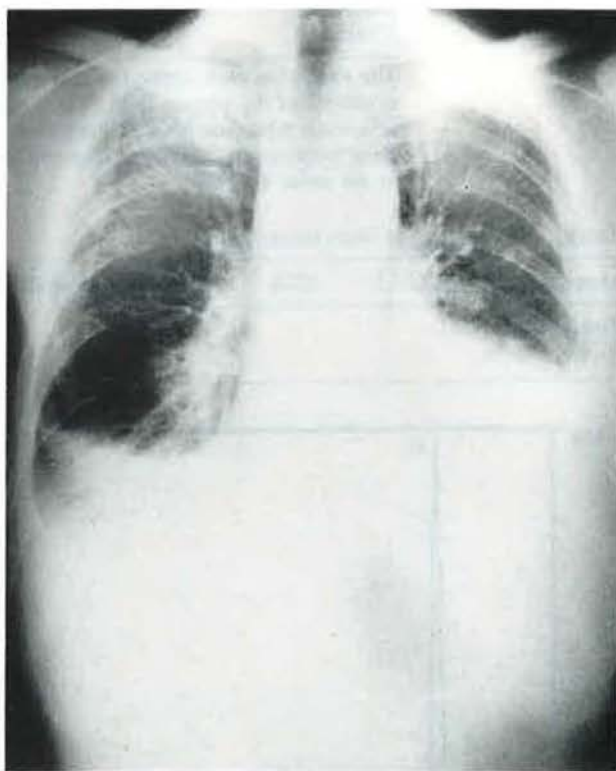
Chest-roentgenogram: bilateral pleural effusion.
